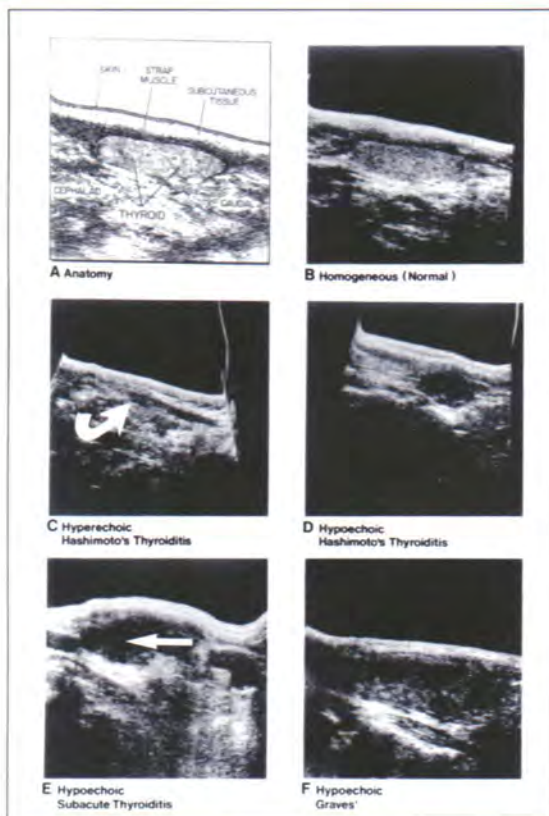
Thyroid gland anatomy and texture. A. Normal anatomy of sagittal section of neck (artistic recreation) showing thyroid gland, strap muscles, subcutaneous tissue, and skin. B. Normal anatomy of sagittal section of neck as seen on thyroid ultrasound. C. Demonstration of an inhomogeneous, relatively hyperechoic gland typical of Hashimoto's Thyroiditis. D. Demonstration of an inhomogeneous, predominantly hypoechoic gland, also seen in Hashimoto's Thyroiditis. E. Demonstration of an inhomogeneous, predominantly hypoechoic gland, seen in the acute phase of silent thyroiditis. F. Demonstration of an inhomogeneous, predominantly hypoechoic gland, seen in Graves' Disease with high antibody titres. Straight arrows - areas of decreased echogenicity. Curved arrows - areas of increased echogenicity.
